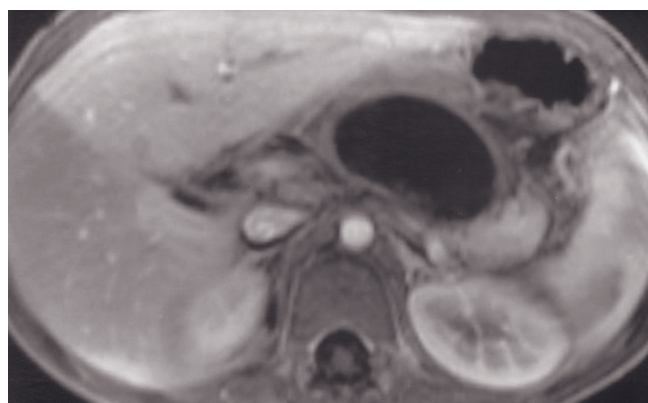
Chemotherapy-induced pancreatitis. T2-weighted ETSE (*a*), T1-weighted fat-suppressed SGE (*b*), immediate postgadolinium T1-weighted SGE (*c*), and 90-s postgadolinium fat-suppressed SGE (*d*) images. In this patient undergoing chemotherapy for breast cancer, there is a heterogeneous low-signal region in the head of the pancreas on the noncontrast T1-weighted fat-suppressed image (*b*) that also shows heterogeneous decreased enhancement (arrows, *c*) on the immediate postgadolinium SGE image (*c*) consistent with pancreatitis secondary to chemotherapy toxicity.
